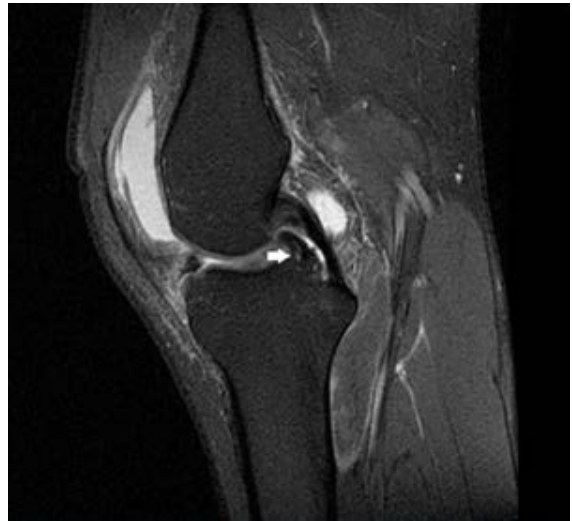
Double posterior cruciate ligament (Double PCL) sign on MRI
